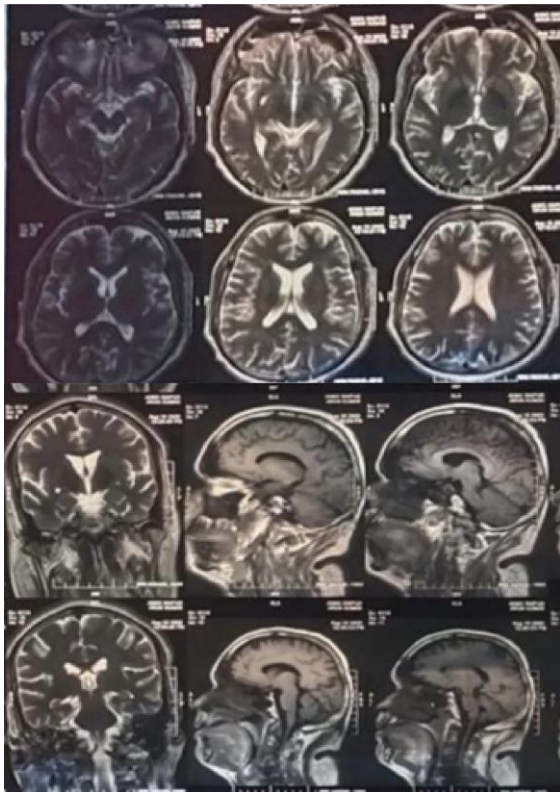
MRI films showing cystic changes in temporal lobes and hyperintensities in corona radiation of bilateral frontal lobes.
